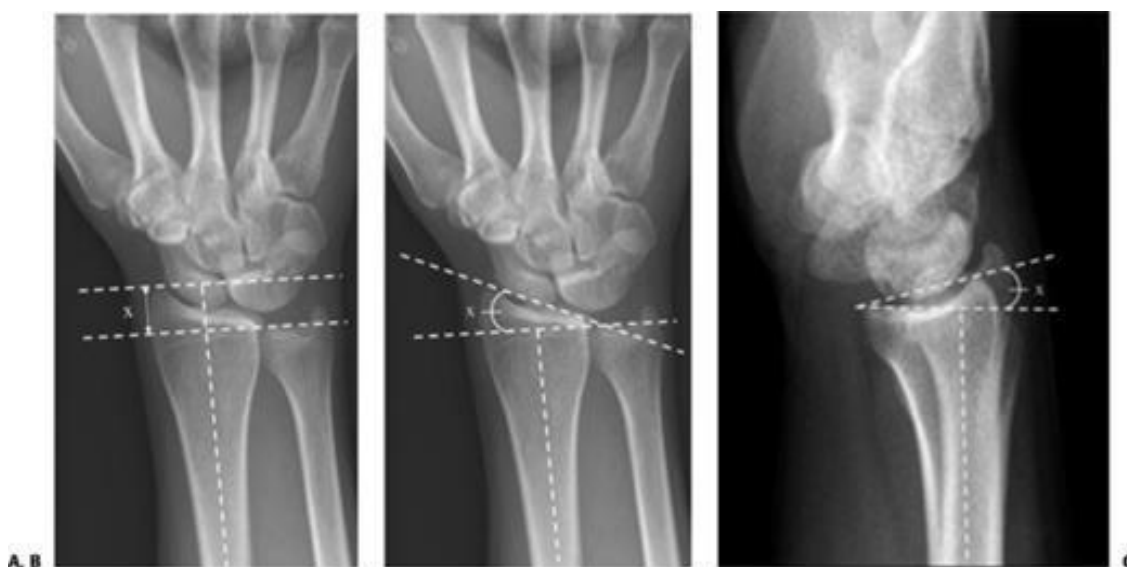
x-ray representation of radiological parameters
